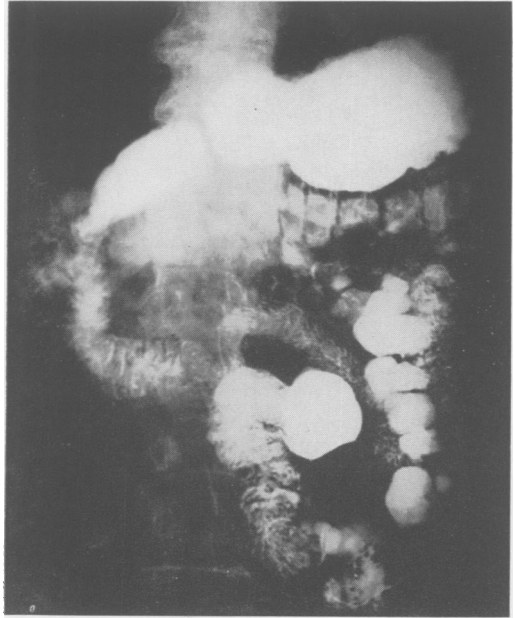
Upper gastro-intestinal roentgenogram showing multiple diverticula of the proximal portion of the small bowel.
